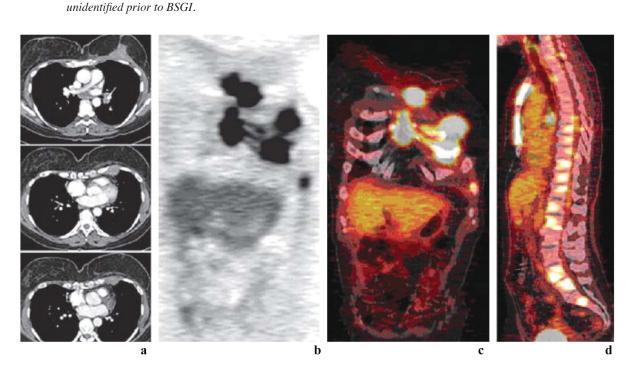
Results of PET/CT in a patient suspected of having recurrent breast carcinoma. Axial contrast-enhanced CT (a), coronal PET (b), coronal fusion (c), and sagittal fusion (d) images show extensive local recurrence involving the breast, sternum, anterior chest wall, and pleura as well as hilar metastases and diffuse bone metastases. (RadioGraphic Octerber 2007 volume 27)
